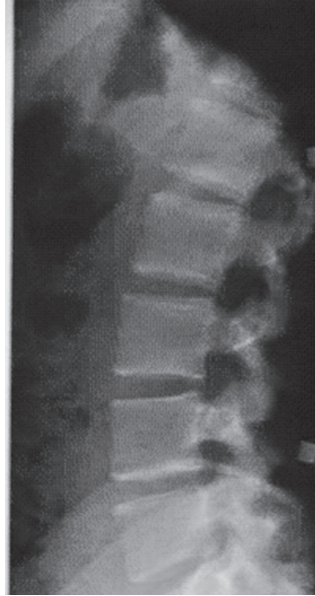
X-ray of the lumbar spine in lateral projection [14]
